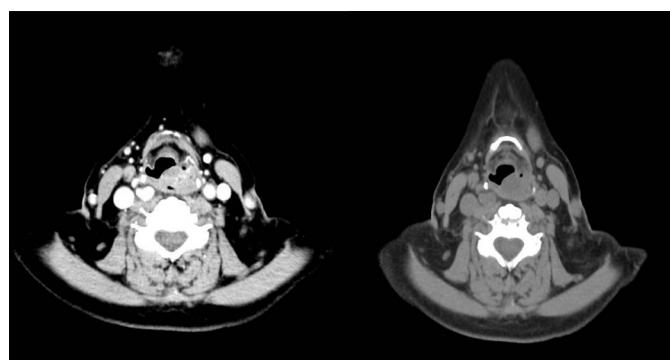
CT imaging of the supraglottic hemangioma. CT: computed tomography.
